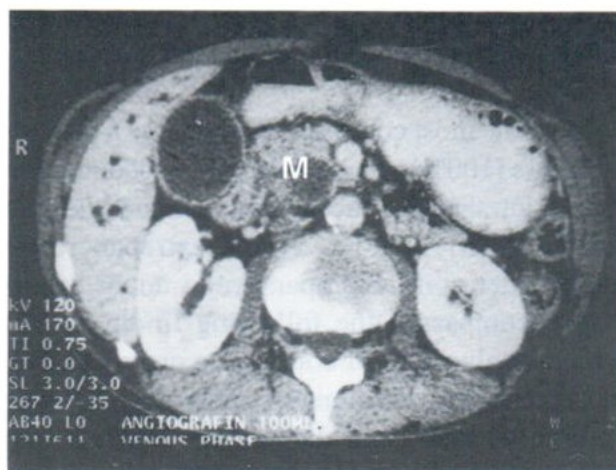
The venous phase dynamic CT scan revealed inhomogeneous enhancement of the pancreatic head mass. (M)
